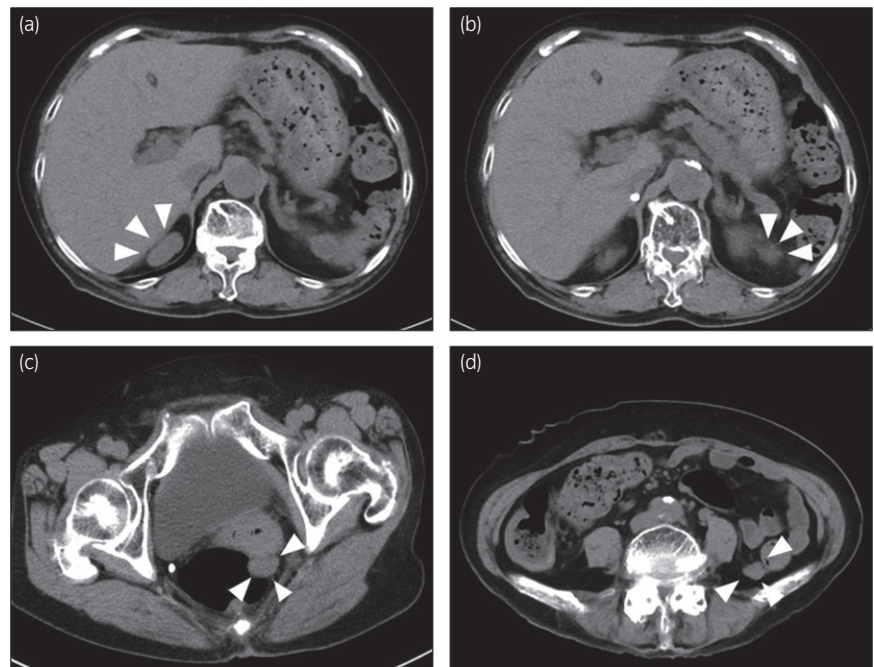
Abdominal CT of tumors in the peritoneal cavity (white arrows). Tumors occurred in the lesion after right adrenalectomy (a), near the spleen (b), the para-rectum (c), and the para-descending colon (d).
